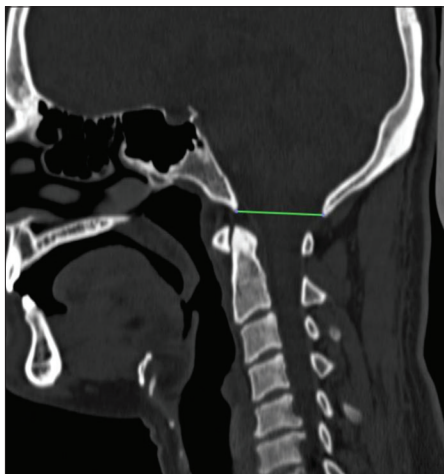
Sagittal section of computed tomography scan showing McRae line
